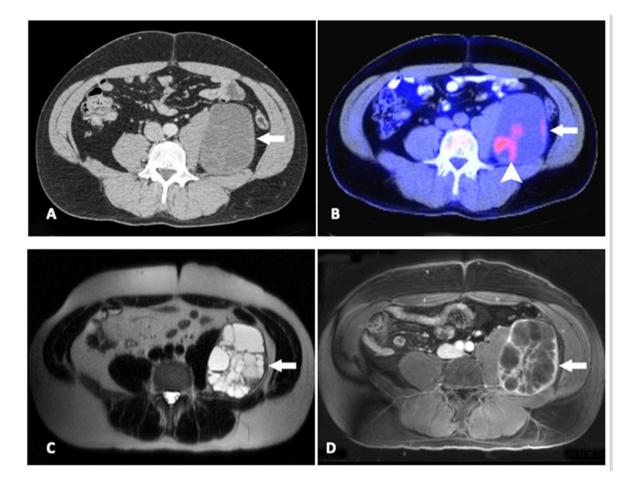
Cystic schwannoma: Contrast enhanced CT scan of the abdomen (A) shows up to 9.9 cm predominantly cystic mass (arrows) with internal septations in the left retroperitoneum causing mass effect on the left psoas muscle. On fused PET-CT image (B) there is low level metabolic activity in most of the lesion, with focus of increased metabolic activity (arrowhead). On T2 HASTE MRI (C), the mass is predominantly hyperintense with septations that enhanced on post contrast T1 with fat saturation image (D). The mass was surgically excised and was pathologically proven to be schwannoma with cystic degeneration.
